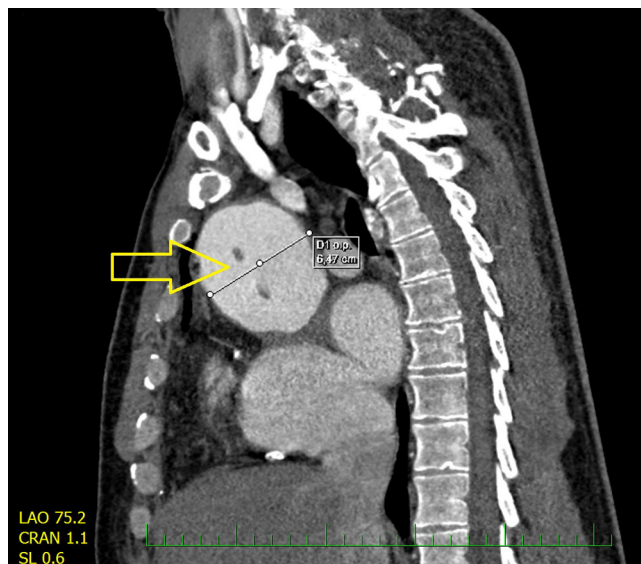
CT image of the peri-aortic pseudoaneurysm (yellow arrow).
